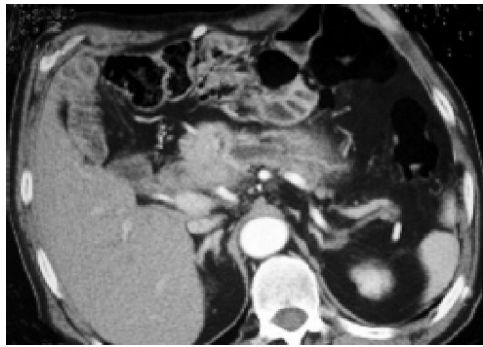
Abdominal CT scan reveals abnormal soft tissue enlargement at the pancreaticojejunostomy.
